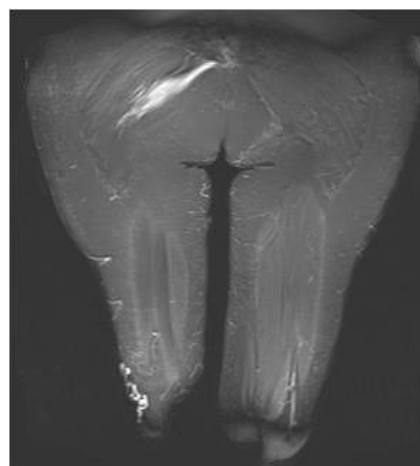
Coronal fat-sat T2-weighted image shows fistul tract originating from perianal region
